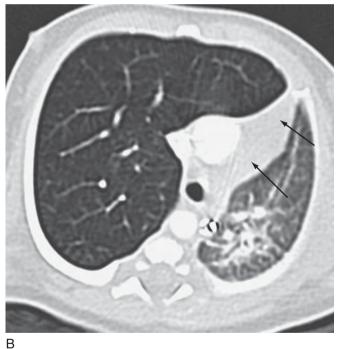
Hyperinflation: 14-day-old boy with respiratory distress. Chest radiograph (A) demonstrates increased lucency in the right upper lobe, causing shift of the mediastinum to the left. Preoperative CT image (\mathbf{B}) confirms the hyperinflation. Notice the decreased number of vessels in the hyperexpanded right upper lobe and the deviation of the thymus (arrows) and other mediastinal structures to the left.
